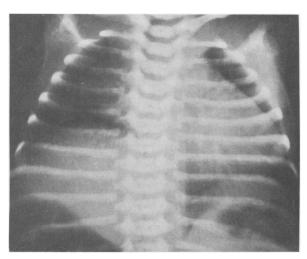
(Case 2) Radiograph of the chest made during the first 24 hours of life showing elevation of the right hemidiaphragm. The left hemidiaphragm is not elevated but at autopsy was found to contain no muscle.
